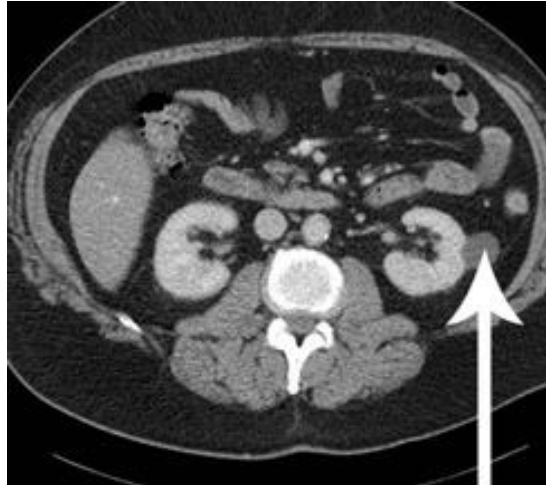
CT Scan showing small Left Kidney Tumour
